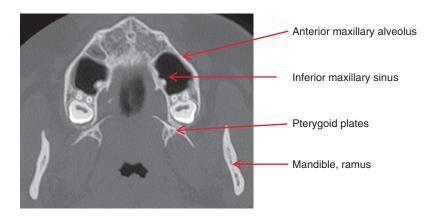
Bone windowed axial CT demonstrating anatomy of the maxillary sinus
